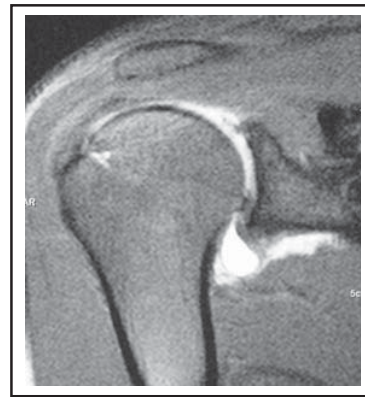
MRI-arthrogram images demonstrating a complex SLAP tear. Note the irregular, almost absent superior labrum
